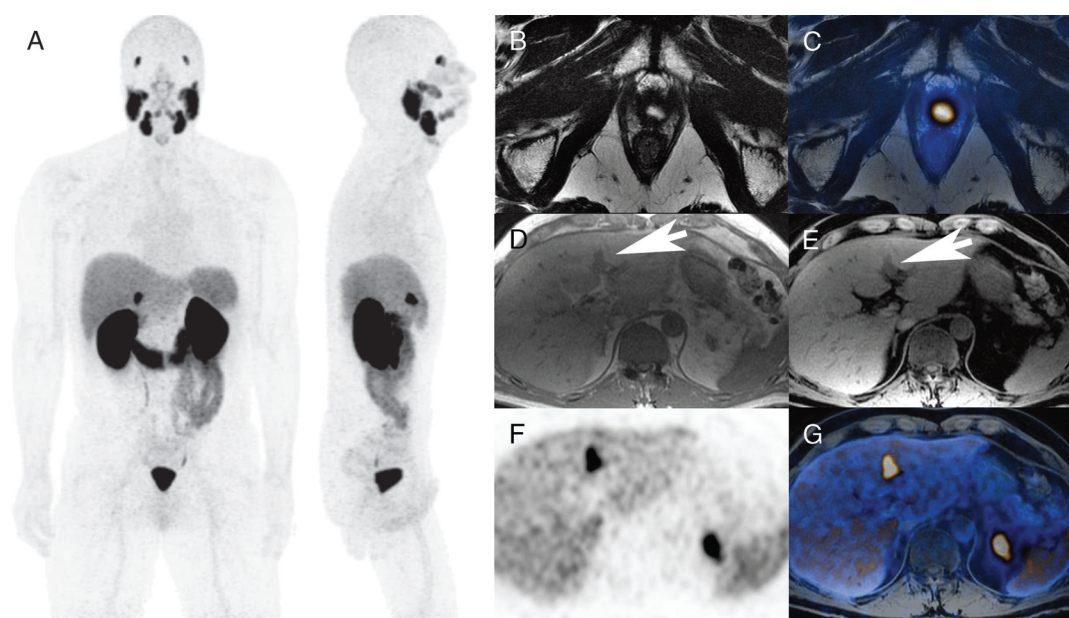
^{68}Ga prostate-specific membrane antigen (PSMA) PET/MRI. A 58-year-old man previously treated with robotic-assisted radical prostatectomy and lymph node sampling 11 years ago for a localized high-risk prostate cancer (pT2c, pN0 [0/2], cM0, R0, Gleason 4 + 4 = 8, preoperative prostate-specific antigen [PSA] 40 ng/mL), who also received salvage radiation therapy combined with 12 months of androgen deprivation for a para-anastomotic recurrence 18 months after surgery, was referred for ^{68}Ga -PSMA PET/MR for restaging because of previous repeated negative PET imaging (^{18}F -choline and ^{68}Ga -bombesin) despite continuously rising PSA values (PSA at time of imaging 30 ng/mL, with an estimated PSA doubling time of 11 months). A, Coronal and sagittal MIP of the ^{68}Ga -PSMA PET/MR showed a single PSMA-positive hepatic lesion of 1.5×2.7 cm with a SUVmax of 25.9. There was no evidence for local recurrence in the prostate bed on (B) axial T2-weighted images or (C) axial-fused PET/MR. No positive lymph nodes, bone metastases, or any sign of ascites was detected. On the axial (D) fat and (E) water weighted T1 3-dimensional dual-echo gradient-echo pulse DIXON-LAVA-Flex sequences, the lesion was slightly hypointense (arrow), with (F) high PSMA accumulation on axial PET and (G) fused PET/MR.
